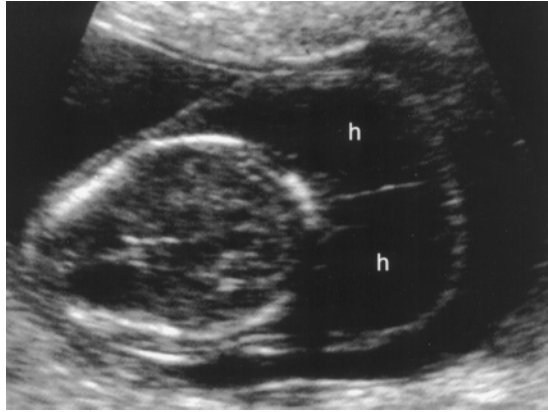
Cystic hygroma. Intrauterine sonogram, obtained at 14 weeks gestation to evaluate vaginal bleeding, shows a large, multiseptated, anechoic mass (b) of the posterior neck.
